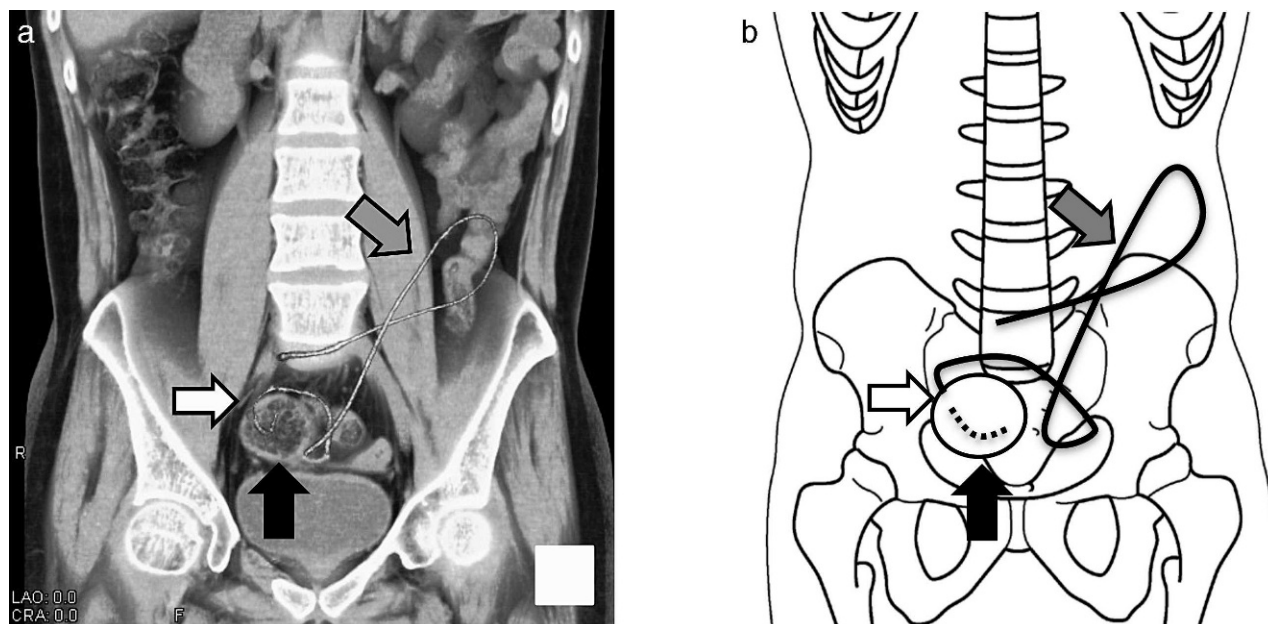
(a) A 3D model constructed from contrast-enhanced abdominal CT. (a,b) The VP shunt catheter (gray ↑) that perforated the lumen of the sigmoid colon (black ↑) and the site of perforation (white ↑) are seen.
